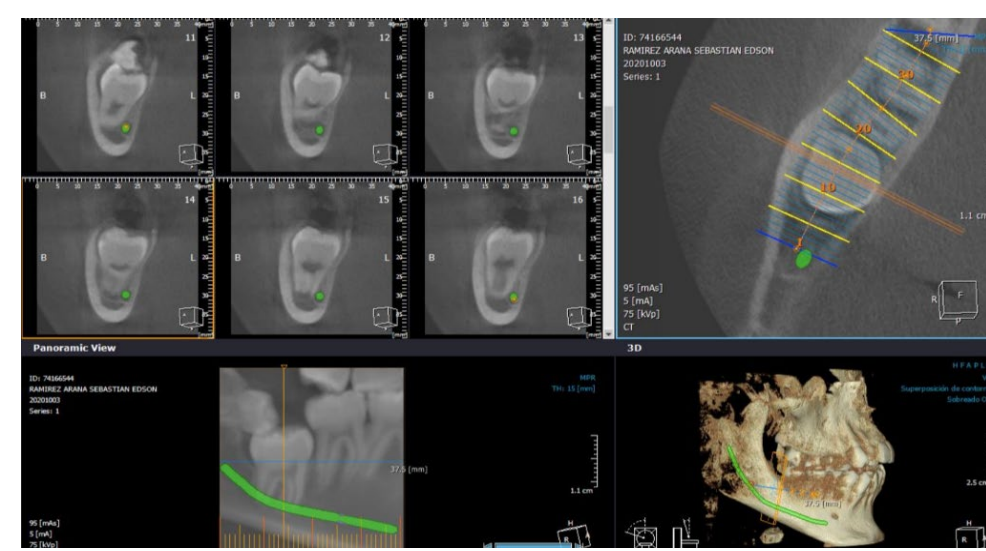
CT Scan with axial slices
